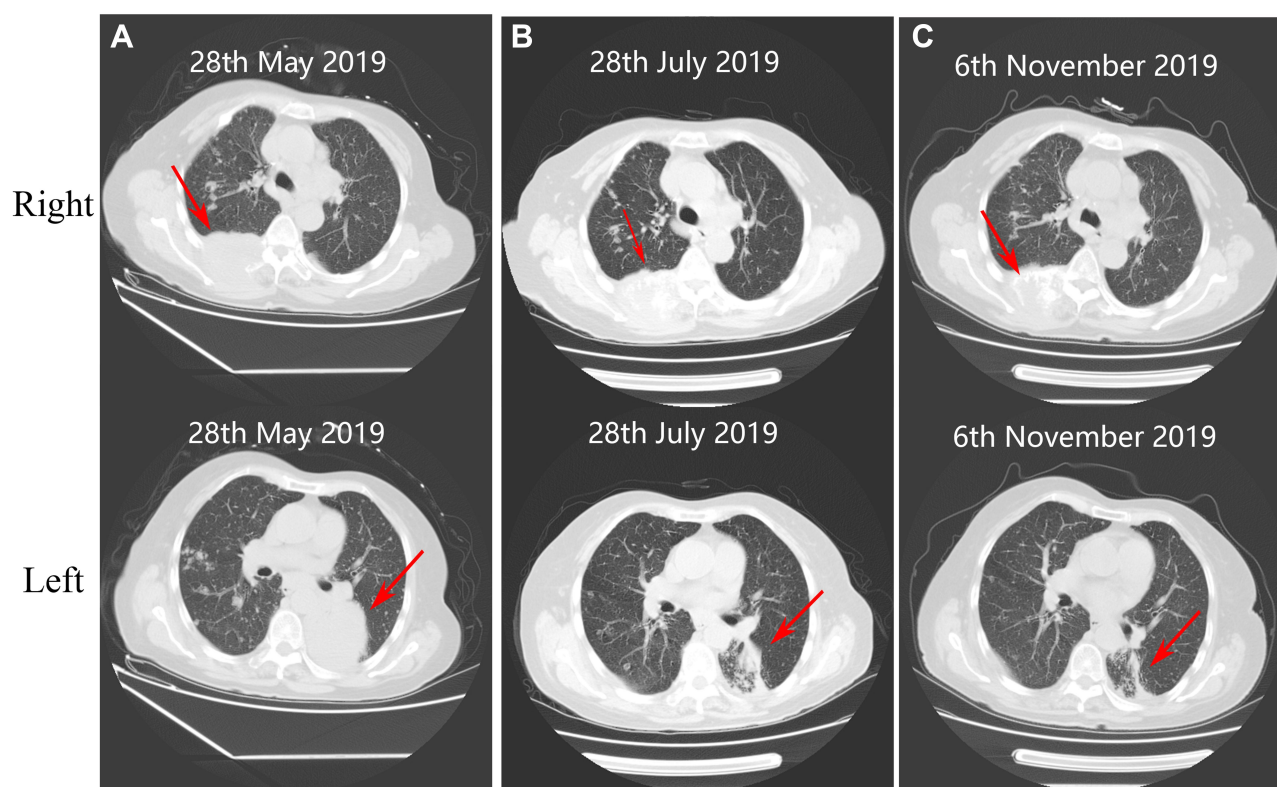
Computed tomography (CT) scans at different time. (A) Baseline imaging (before treatment) of right and left pulmonary lesions, respectively. After (B) 1 month (July 28, 2019) and (C) 4 months (November 6, 2019) of treatment, the mass in the left pulmonary lesion reduced significantly and the right pulmonary lesion decreased slightly, compared with that of baseline imaging.
